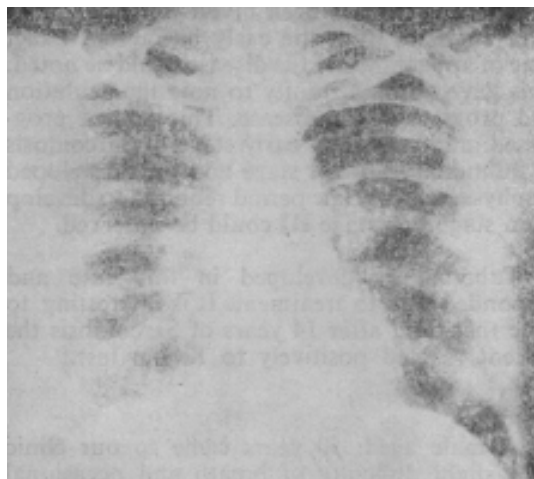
X-ray of the chest shows BHL + mottling of lung on both sides of chest.
